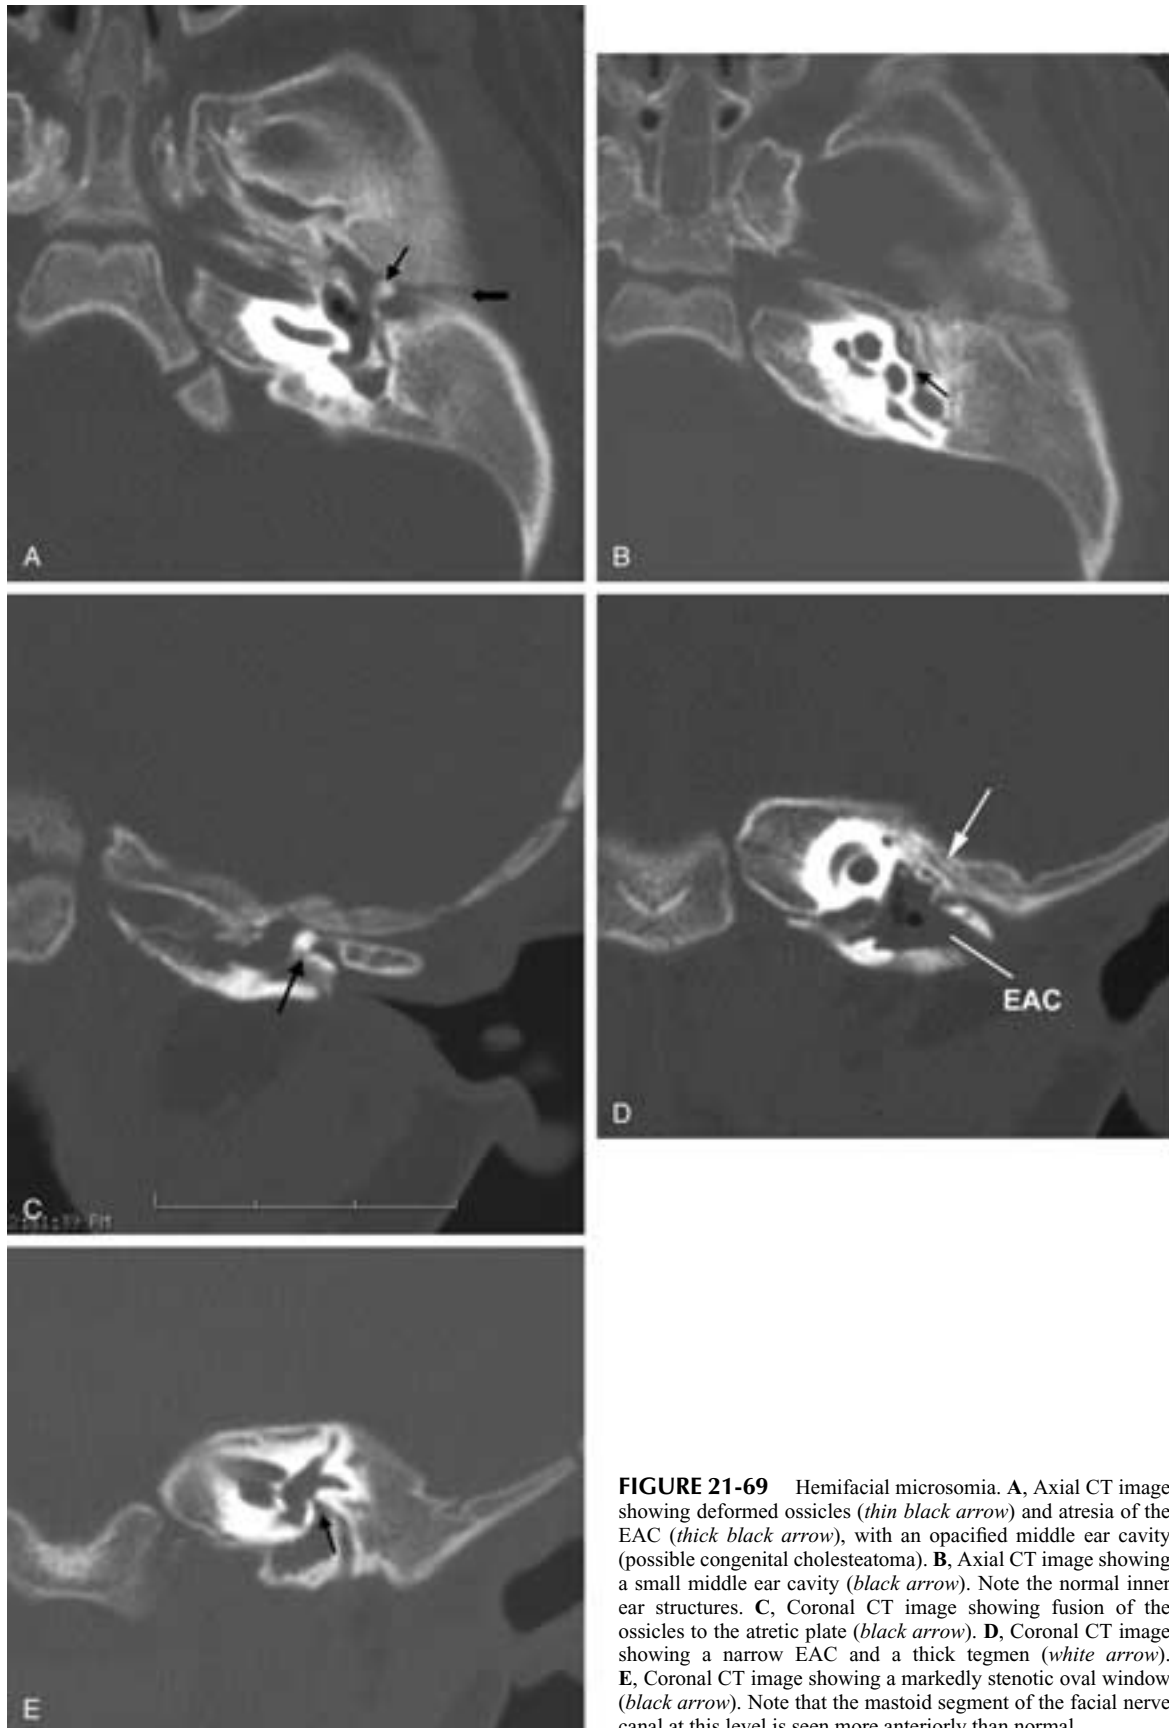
Hemifacial microsomia. A, Axial CT image showing deformed ossicles (*thin black arrow*) and atresia of the EAC (*thick black arrow*), with an opacified middle ear cavity (possible congenital cholesteatoma). B, Axial CT image showing a small middle ear cavity (*black arrow*). Note the normal inner ear structures. C, Coronal CT image showing fusion of the ossicles to the atretic plate (*black arrow*). D, Coronal CT image showing a narrow EAC and a thick tegmen (*white arrow*). E, Coronal CT image showing a markedly stenotic oval window (*black arrow*). Note that the mastoid segment of the facial nerve canal at this level is seen more anteriorly than normal.
